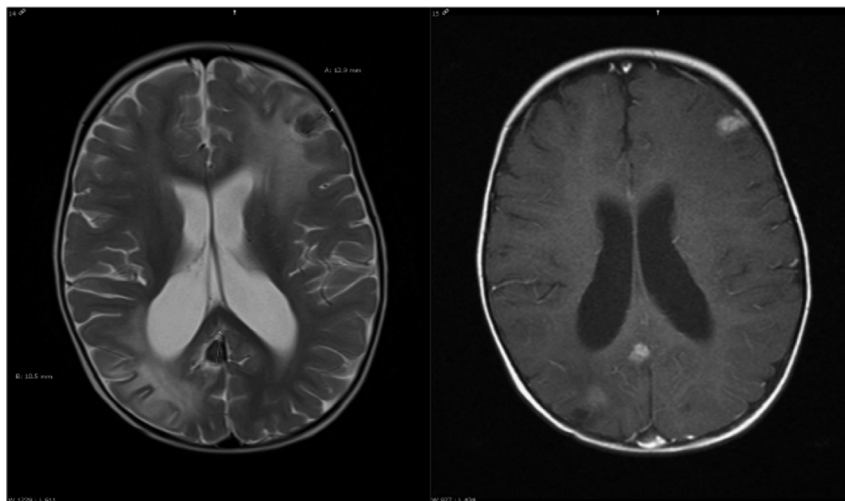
Patient 1: axial T2 (left) and T1 (right) contrast enhanced MRI-cerebrum show multiple lesions intracerebral at the corticomedullary junction, with low T2 signal with surrounding edema and rim enhancement.
